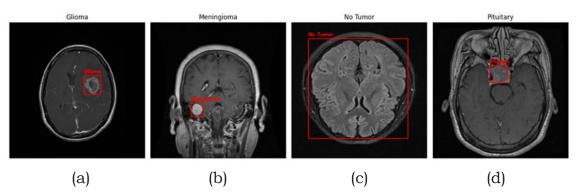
Examples of MRI images with bounding box annotations for each tumour category: (a) Glioma, (b) Meningioma, (c) No Tumour, and (d) Pituitary
